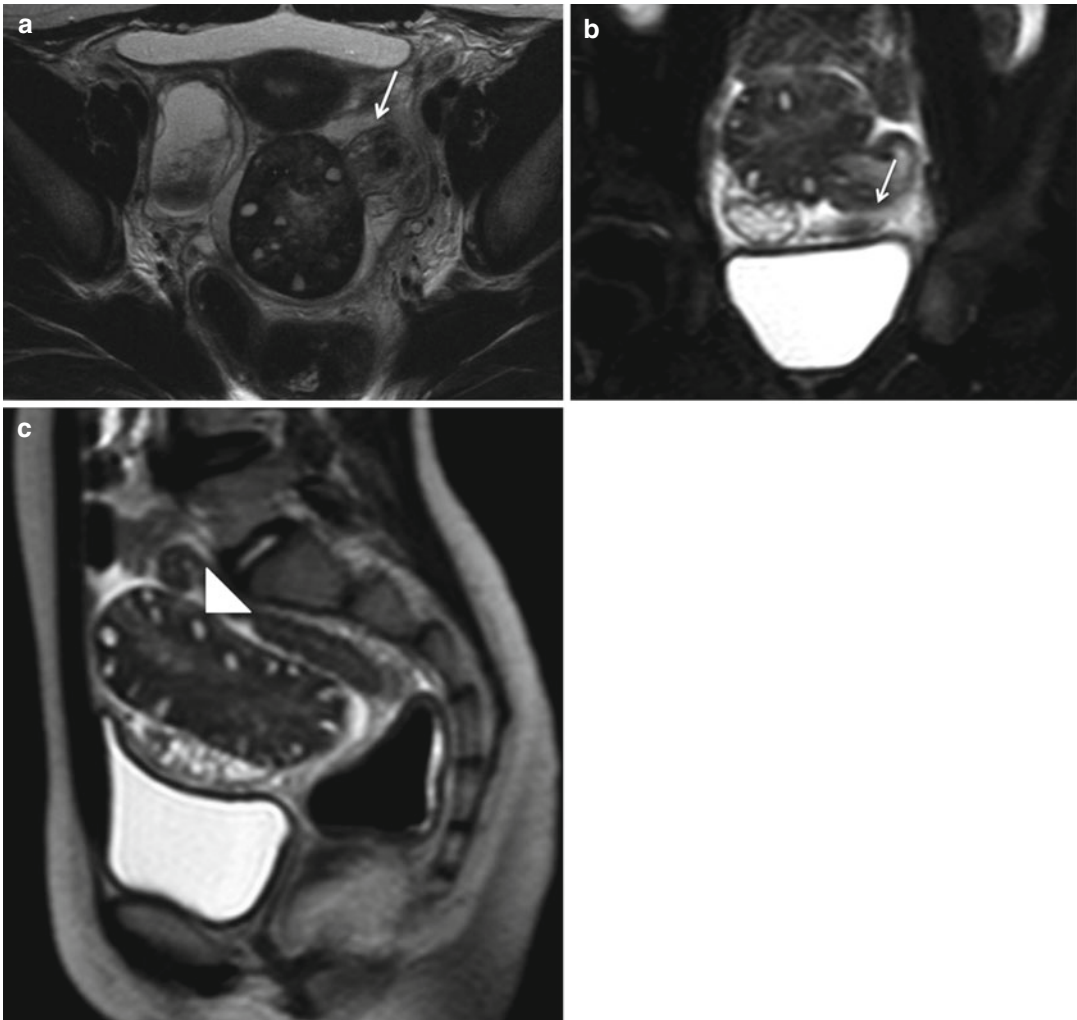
MRI findings of ovarian torsion in a 12-year-old girl: all the images of T2-weighted show an enlarged left ovary with central hyperintense signal for stromal
